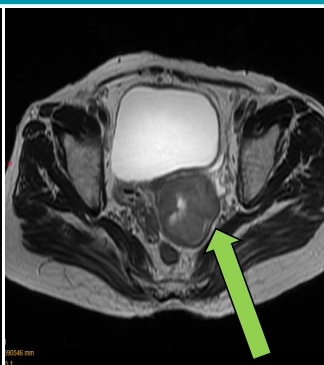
T2-weighted MRI (coronal plane) demonstrating the lesion
